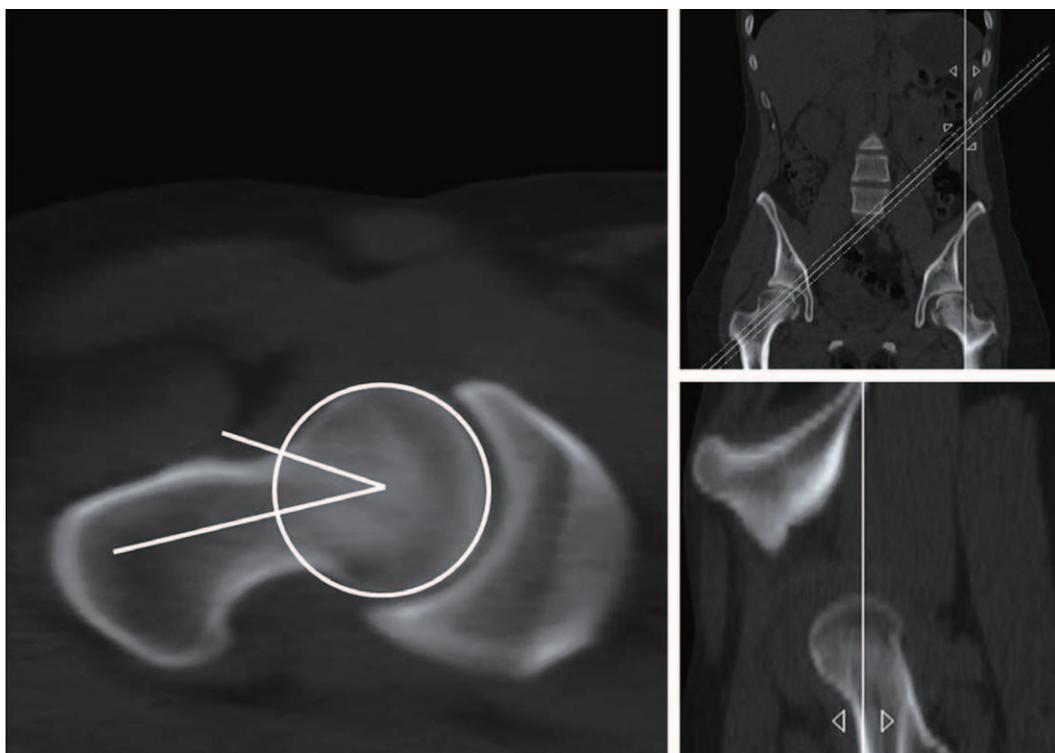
Alpha angle measurement with reformatted pelvis multi-detector computed tomography scan.
